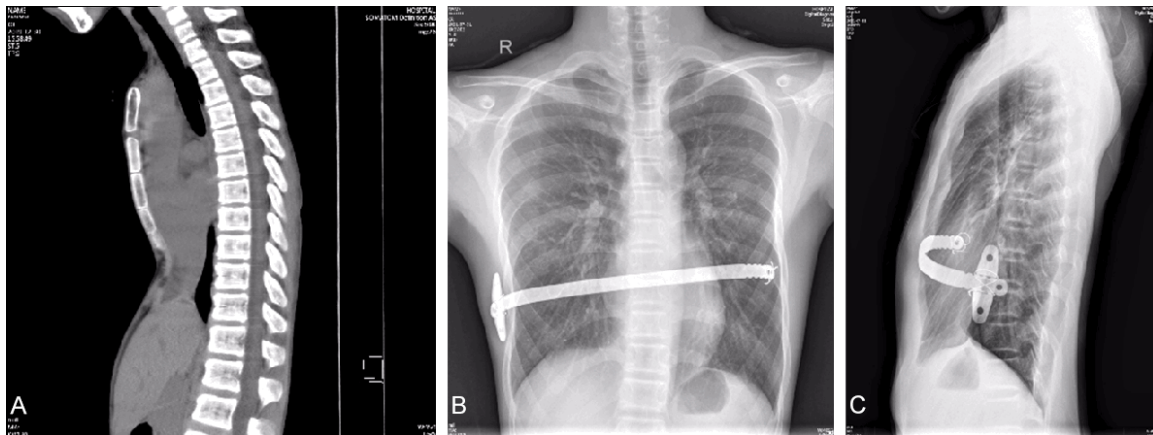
Contrast radiographs of a 14-year-old child before and after surgery. A: Before the operation; B: 1 month after the operation; C: 3 months after the operation.
